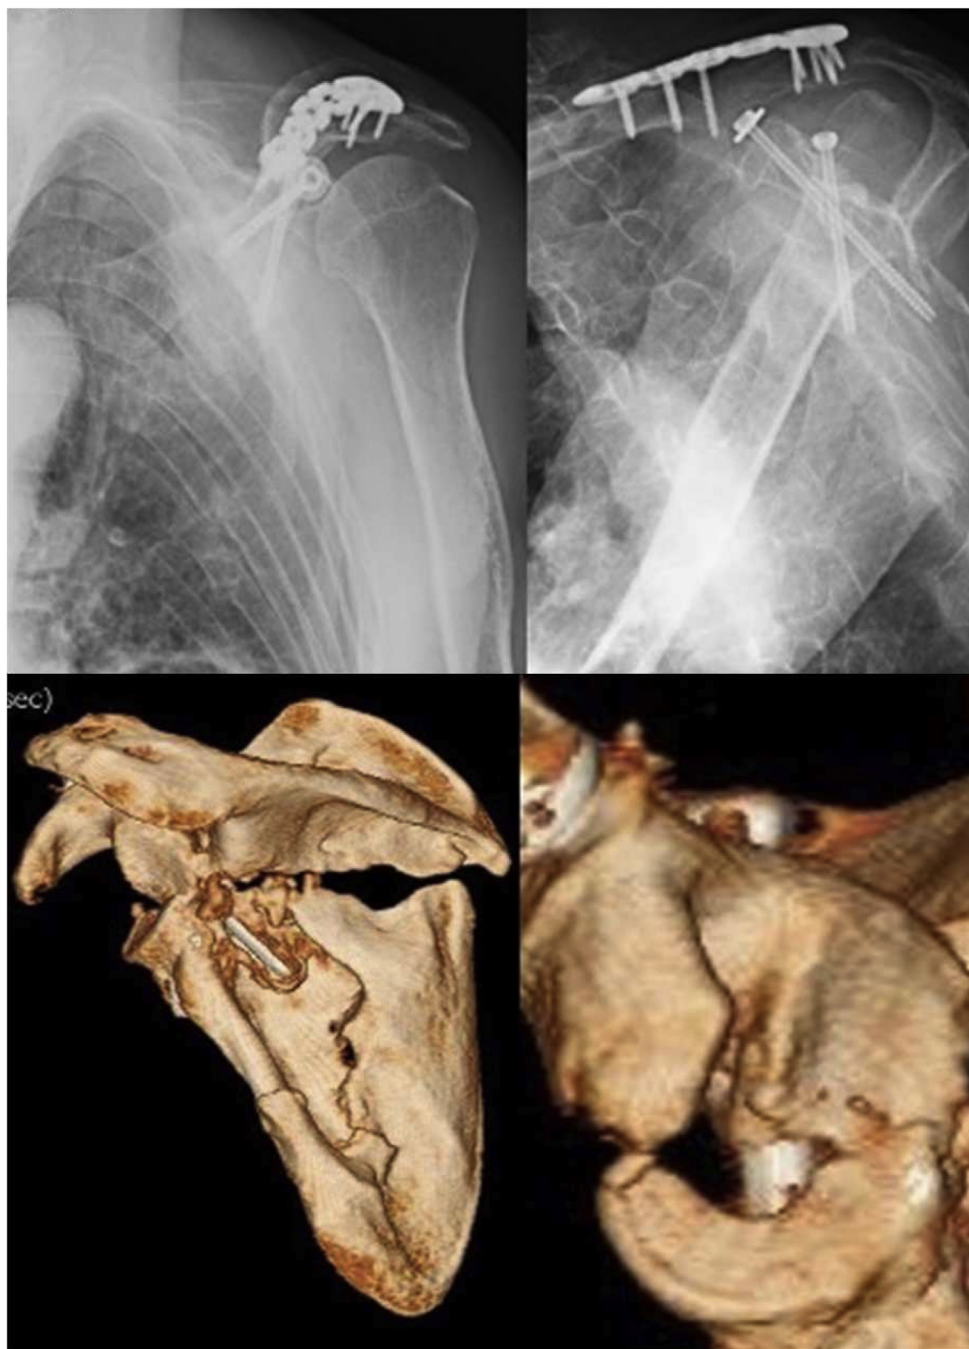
X-ray and CT on the sixth postoperative month (before reconstruction) showing malunion of the glenoid fossa. CT, computed tomography.
